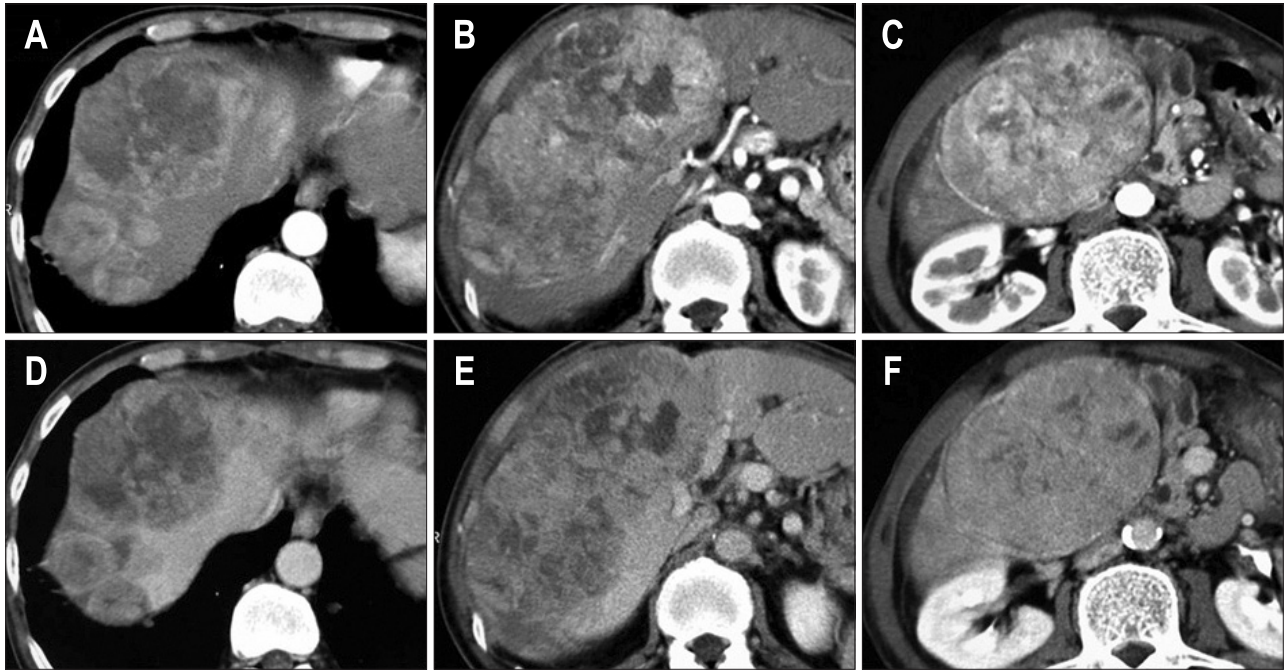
Contrast-enhanced computed tomography showed a large heterogeneous dense mass with enhancement involving the right hepatic lobe. The tumor was enhanced in the arterial phase (A-C) and washed out in the delayed phase (D-F), with central necrosis.
